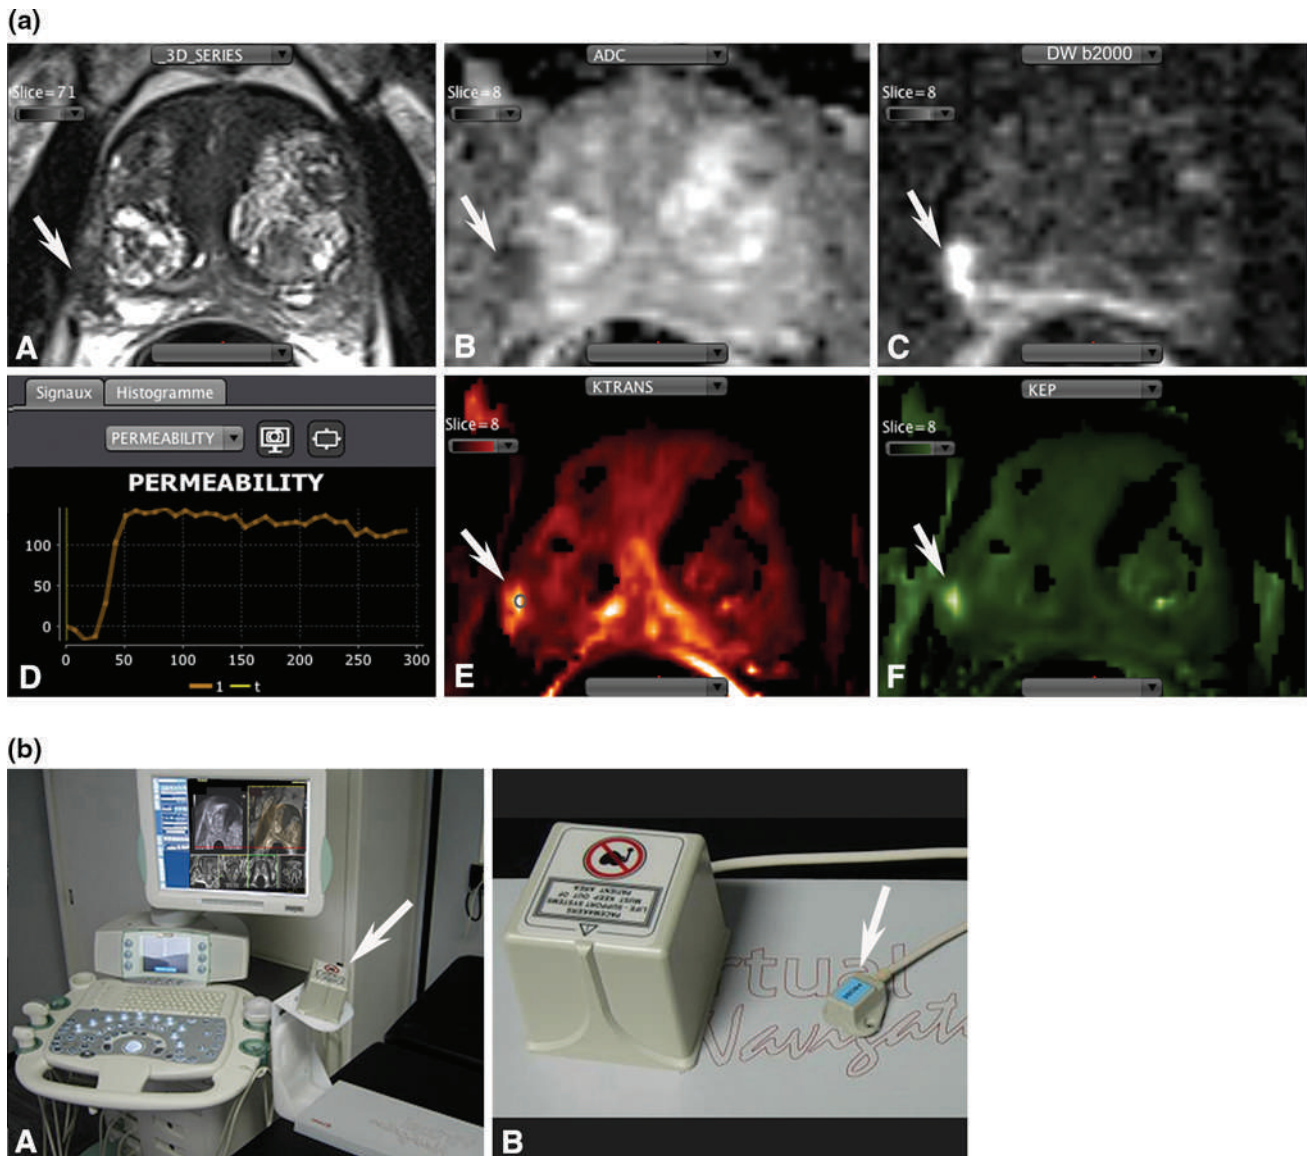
Sensor-based image registration. 67-year-old man. Raising PSA (7 ng/mL). a mp-MRI: low signal intensity focus in the right PZ (arrow, A), with low ADC value and high intensity signal on source DW images at high b -value (arrow
